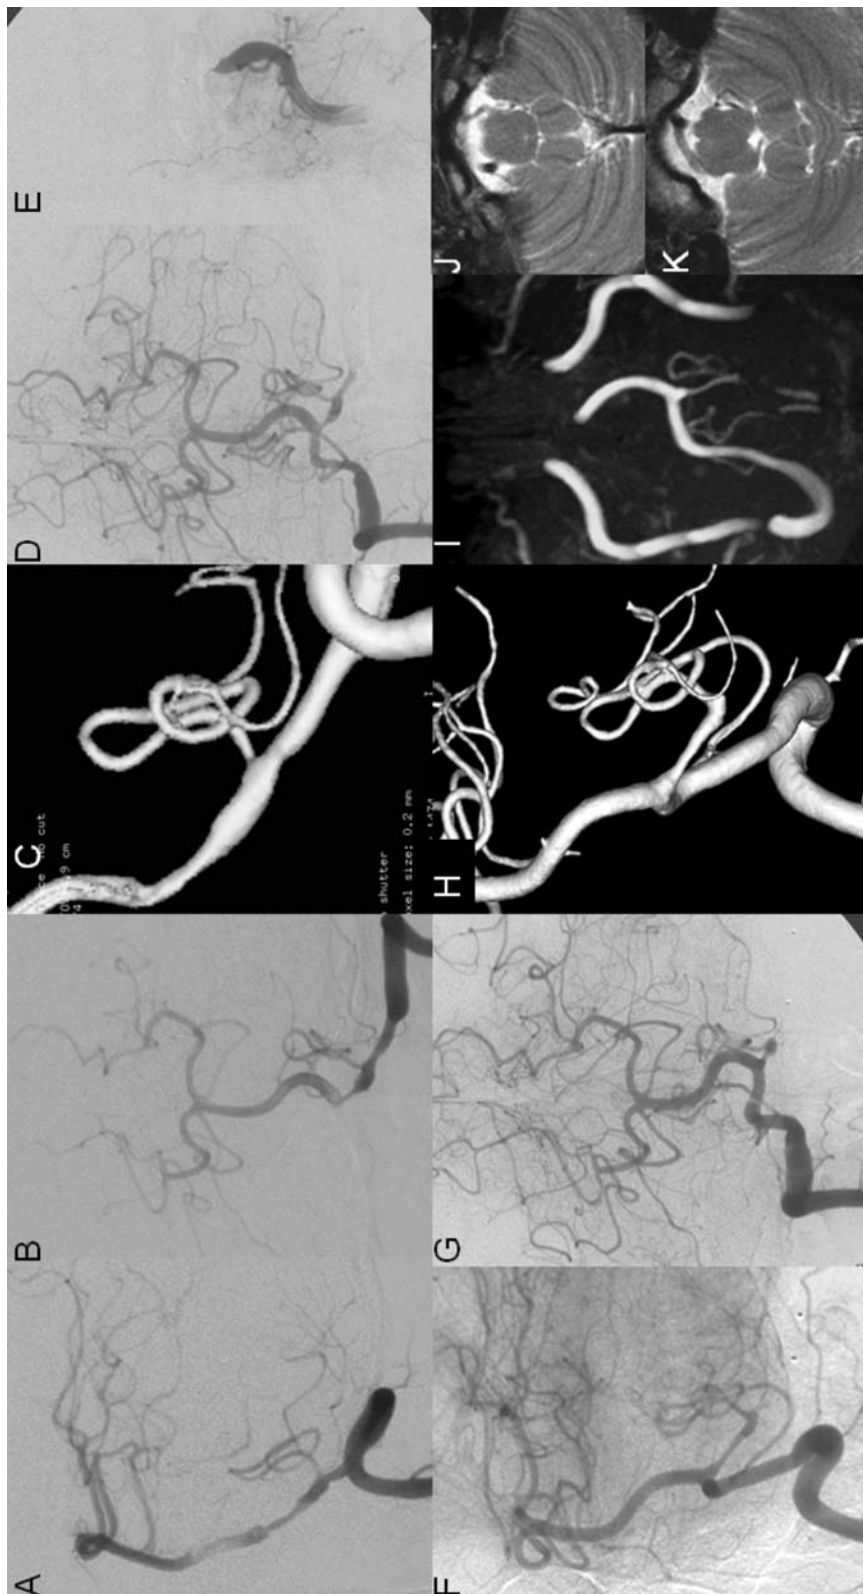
Patient 9: A 38-year-old female presented with head and neck pain, which worsened over the course of two days and was accompanied by nausea and photophobia. Cranial CT showed SAH. *Frames A–C*: Angiography showed irregular stenosis in the left V4 segment of the dominant left vertebral artery with involvement of the origin of the left posterior inferior cerebellar artery. Proximal occlusion was performed at the level of C1. Right vertebral artery injection after detachable balloon occlusion of the healthy vessel segment proximal to the dissection showing opacification of the left posterior inferior cerebellar artery through the contralateral vertebral artery. Although the dissection was still opacified, there was no recurrent bleeding. *Frames F–H*: Control angiography at 10 months demonstrating remodelling of the segment between the posterior inferior cerebellar artery and the vertebral-basilar junction while the caecum of the dissection is not opacified anymore. *Frames I–K*: MRI at 22 months showing a normal contour of the vessels and no abnormal signals either in the brain tissue or the vessel wall. The patient had a good clinical outcome, with a Kamovsky score of 90
